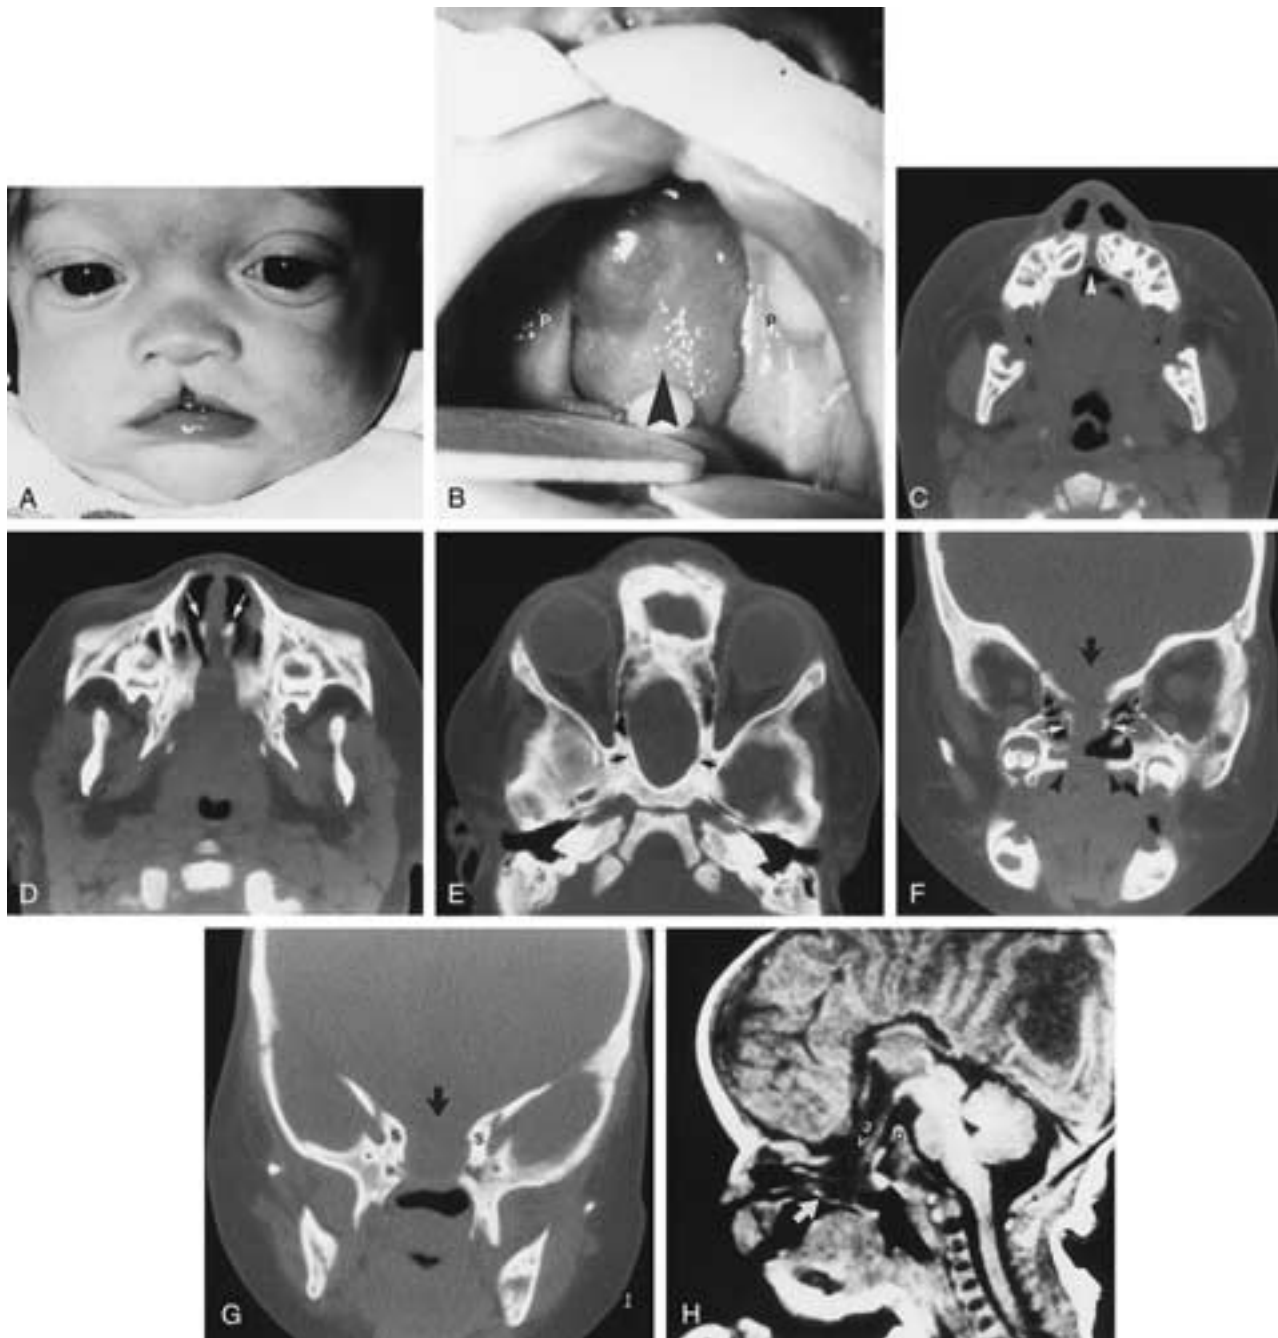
Craniofacial cerebral dysraphism. True midline cleft vermilion and philtrum with *hypertelorism* in a 4-month-old boy with progressive compromise of the airway. A, Facial clefting. B, View through the open mouth toward the palate demonstrates cleft palate with wide separation of the palatal shelves (*P*) and downward protrusion of a soft-tissue mass (*arrowhead*) into the oral cavity. CT in the axial (C to E) and coronal (F and G) planes demonstrates midline clefting in the superior alveolar ridge (*arrowhead* in C), abnormally wide nasal septum with cleft ethmoids (*white arrows* in D and F), cleft palate (*black arrowheads* in F), and a soft-tissue mass (*black arrow* in F and G) that bulges inferiorly through the sharply margined ovoid canal (*black arrows* in E) in the cleft sphenoid (*S*) and ethmoid bones. H, Sagittal T1-weighted MR image demonstrates callosal agenesis and a transsphenoidal-ethmoidal cephalocele (*white arrows*) containing the third ventricle (*3V*), hypothalamus, and portions of the frontal lobes. The cephalocele extends downward into the oral cavity through the cleft sphenoid just anterior to the dorsum sellae (*D*). (Courtesy of Dr. Sharon Byrd, Chicago.)
